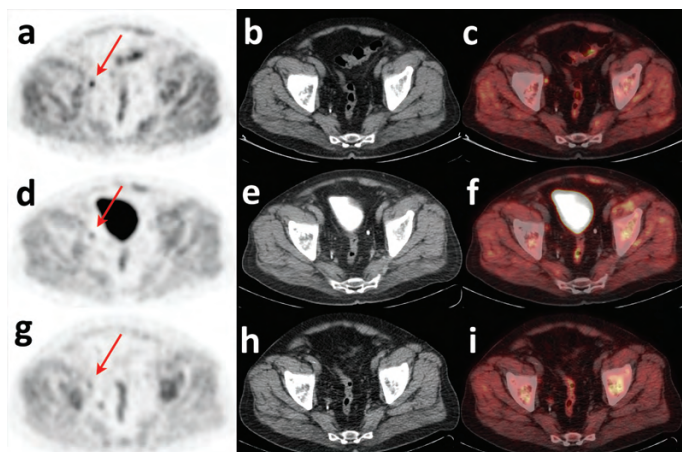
[^{18}F]-fluoromethylcholine PET/CT images of a 74-year-old patient with persisting, but decreasing, activity in a right para-iliac lymph node after SBRT. PET, low-dose CT, and fused PET/CT images before (A-C) SBRT, 20 months (D-F) and 32 months (G-I) after SBRT, respectively.
